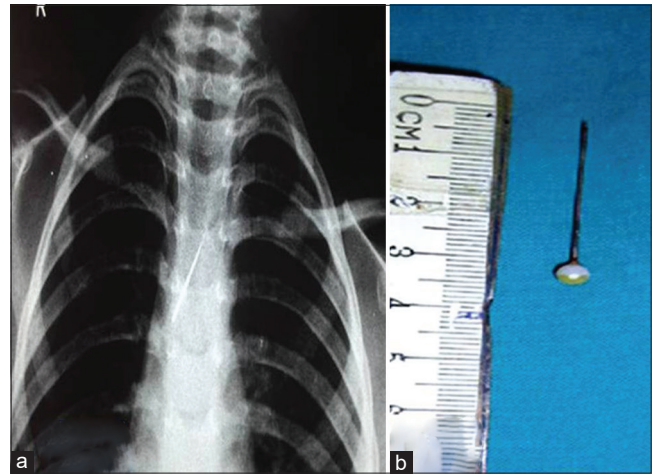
(a) X-ray of chest showing a sharp radiopaque long FB in tracheobronchial airway; (b) Head scarf pin removed from the right bronchus
